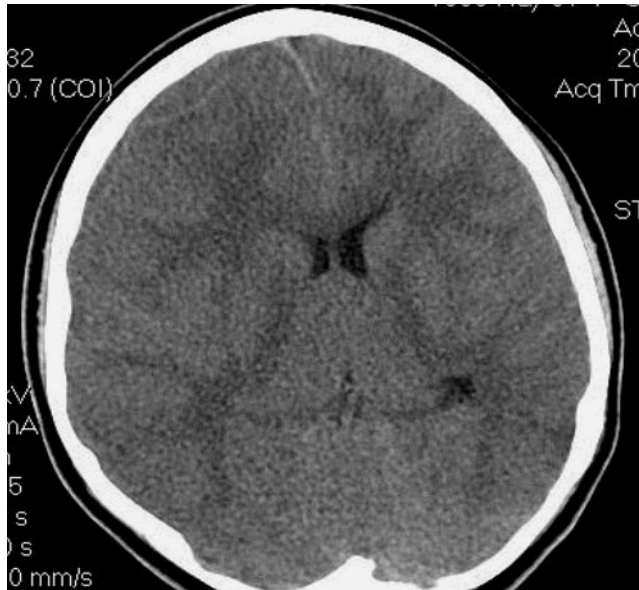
CT scan showing an epidural abscess in the right frontal area.
